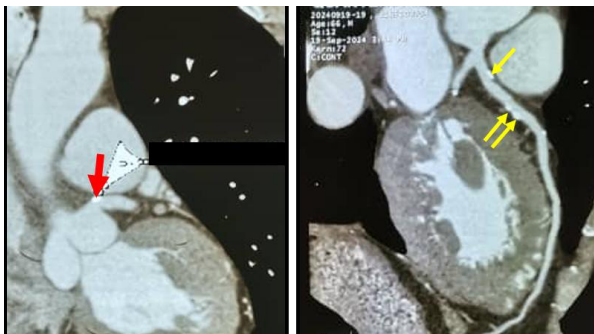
Results of coronary computed tomography angiography (CCTA) highlighting: A: The presence of a proximal plaque responsible for a stenosis of approximately 20% (CAD-RADS 1) (red arrow) on the common trunk. B: The presence of numerous proximal plaques with stenoses of approximately 50 to 69% (CAD-RADS 3) without intramyocardial bridge (yellow arrows) on the left anterior descending artery (LAD).
